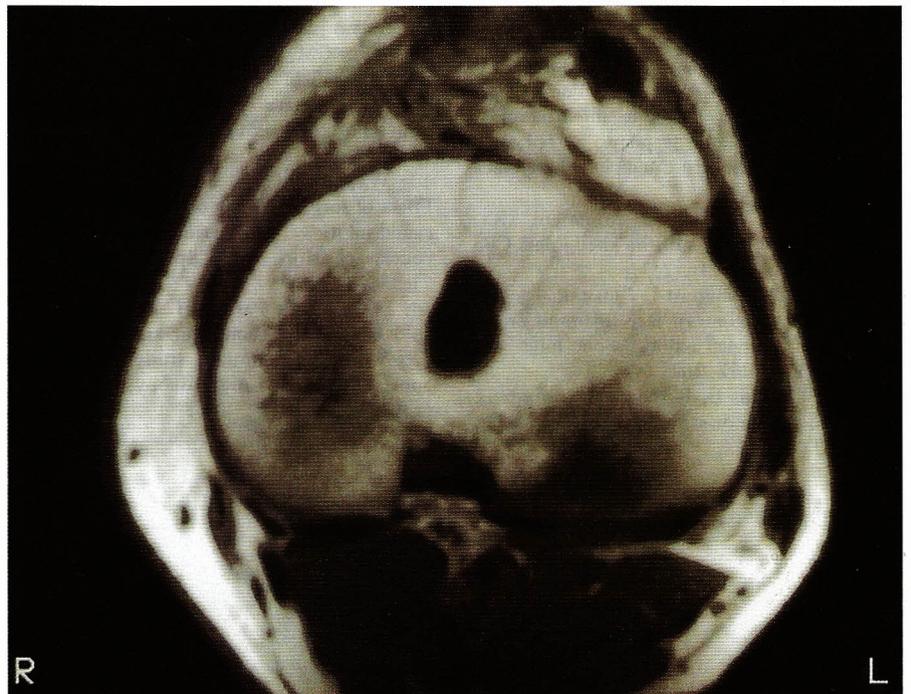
Check MRI scan at 12 mo, showing anatomical alignment of the graft.
